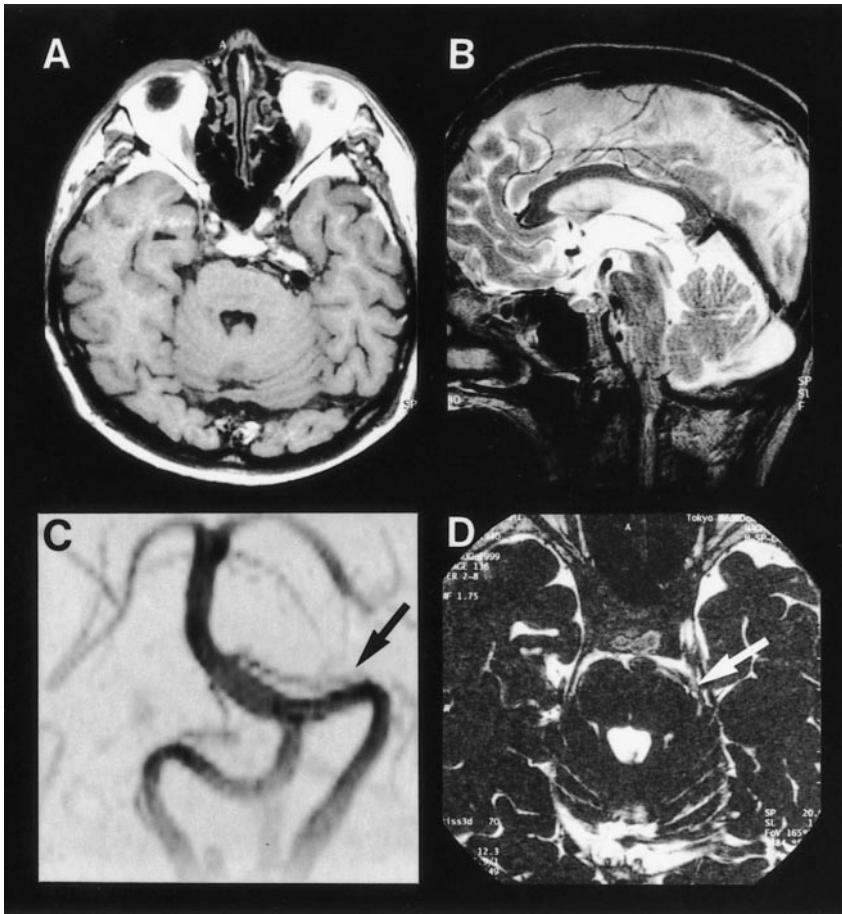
Magnetic resonance images showing the upward displacement of brainstem and ventral compression of the pons by the left vertebral artery on the T1 weighted axial (A) and T2 weighted sagittal (B) images. Magnetic resonance angiography (C) and constructive interference in steady-state image (D) demonstrating marked elongation of the left vertebral artery compressing the root entry zone of the left trigeminal nerve (arrows)
